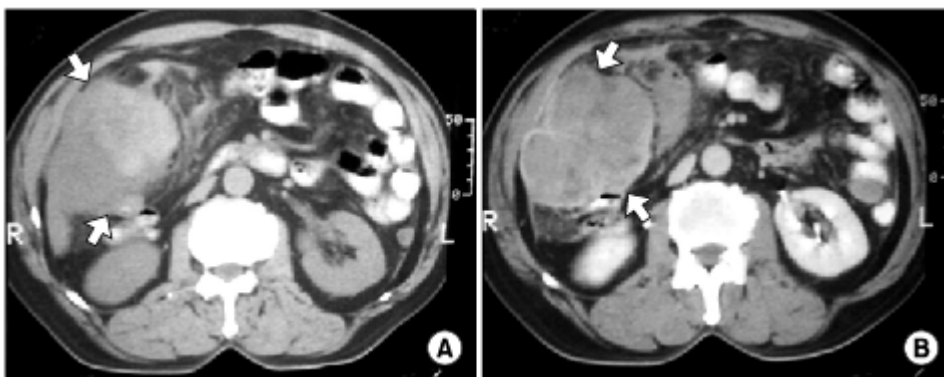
(A) Pre-contrast enhanced computed tomogram (CT) revealed a 10×8 cm lobulate, marginated, heterogenous, attenuating mass (arrow) with internal high attenuated region, reflecting the hemorrhagic foci. (B) Post-contrast enhanced CT scan revealed moderate heterogeneous enhancements (arrow) with moderate peritumoral infiltrations and ascites.
